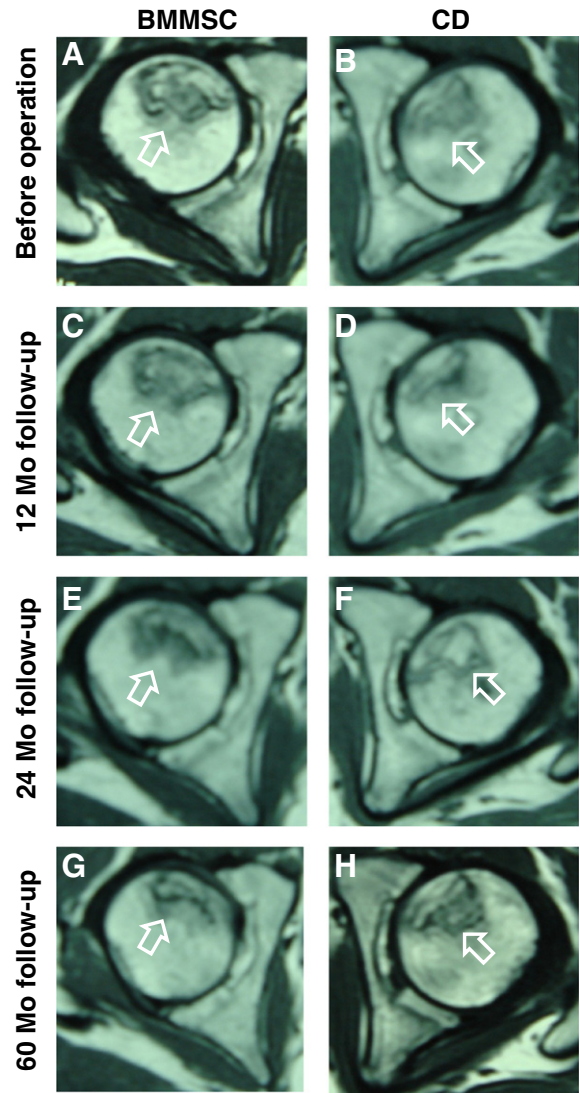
Transversal T1-weighted magnetic resonance images of two femoral heads. The left panels (A, C, E, and G) were from a hip treated with BMMSC transplantation, the right panels (B, D, F, and H) were from a hip treated with core decompression. Arrows indicate the necrotic lesions.
